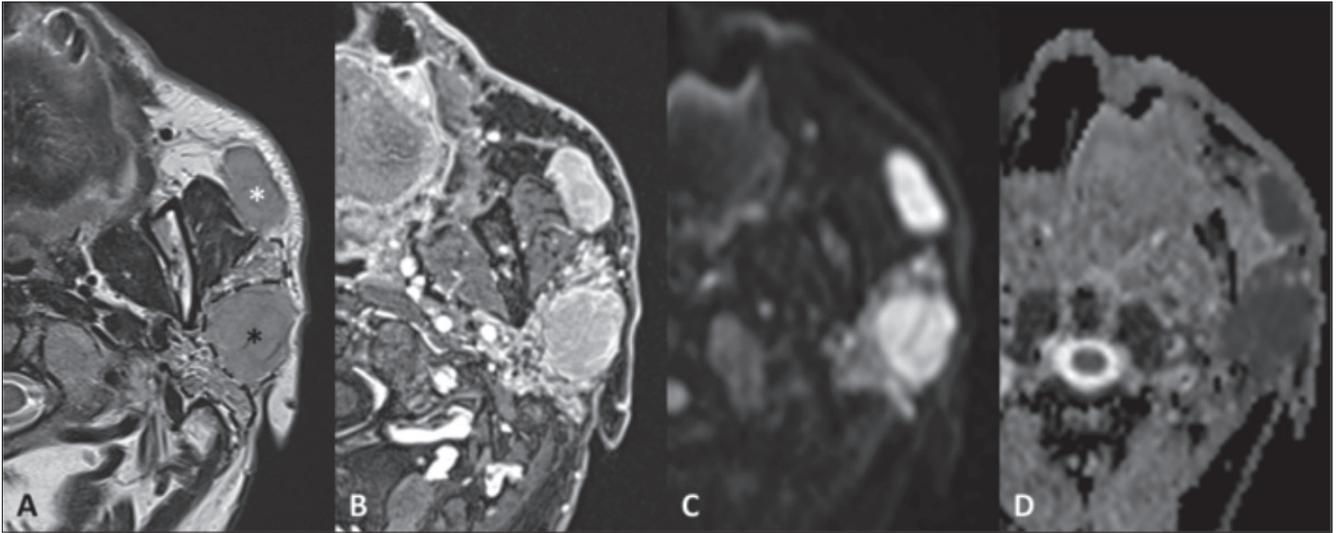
Lymphoma of mucosa-associated lymphoid tissue (MALT) in a patient with primary Sjögren's syndrome. MR TSE T2 (A), VIBE after contrast administration (B), DWI b1000 (C) with ADC map (D). MR scan shows a lesion of the superficial portion of the parotid gland (black asterisk), displacing the remaining part of the gland (dashed line), with enhancement and high diffusion restriction. A second lesion with similar features is evident at the anterior extension of the gland (white asterisk).
